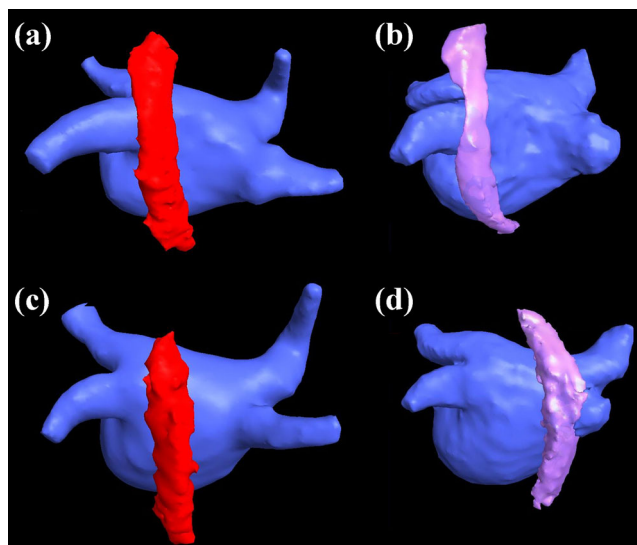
Examples of the shift of the esophagus between CT and 3DRA models, posteroanterior view. a Minimum shift of the esophagus (CT model, column B), b minimum shift of the esophagus (3DRA model, column B), c maximum shift of the esophagus (CT model, column B), and d maximum shift of the esophagus (3DRA model, column E)
